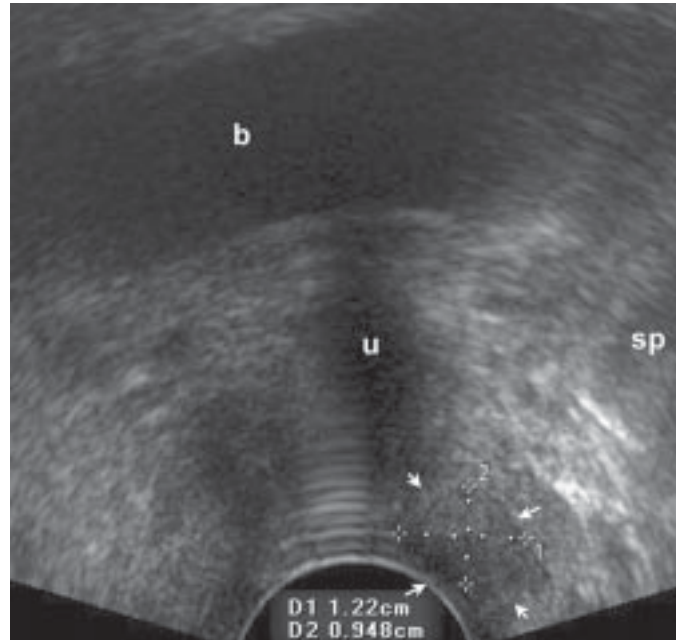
Transvaginal ultrasonography demonstrates an irregular isoechoic nodule (arrow), measuring 1.22 × 0.94 cm, is locating near the distal urethra. (b = bladder, u = urethra, sp = pubic symphysis)
